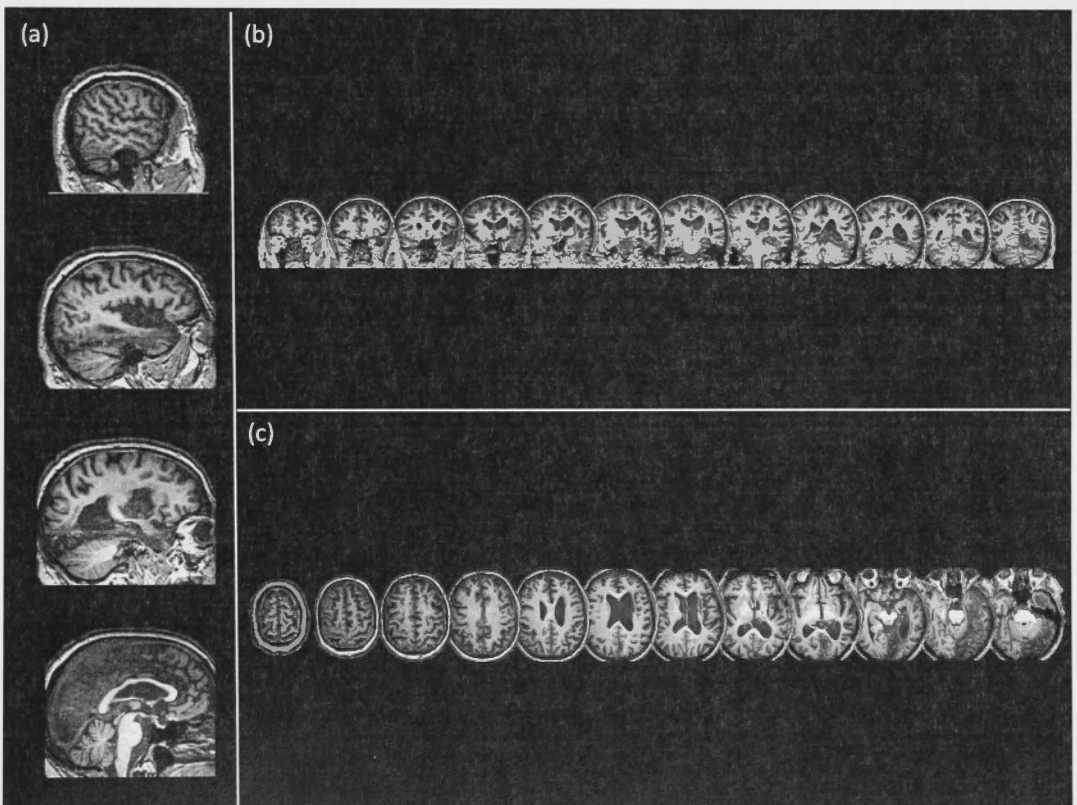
T1-weighted brain MR images of patient BN:
